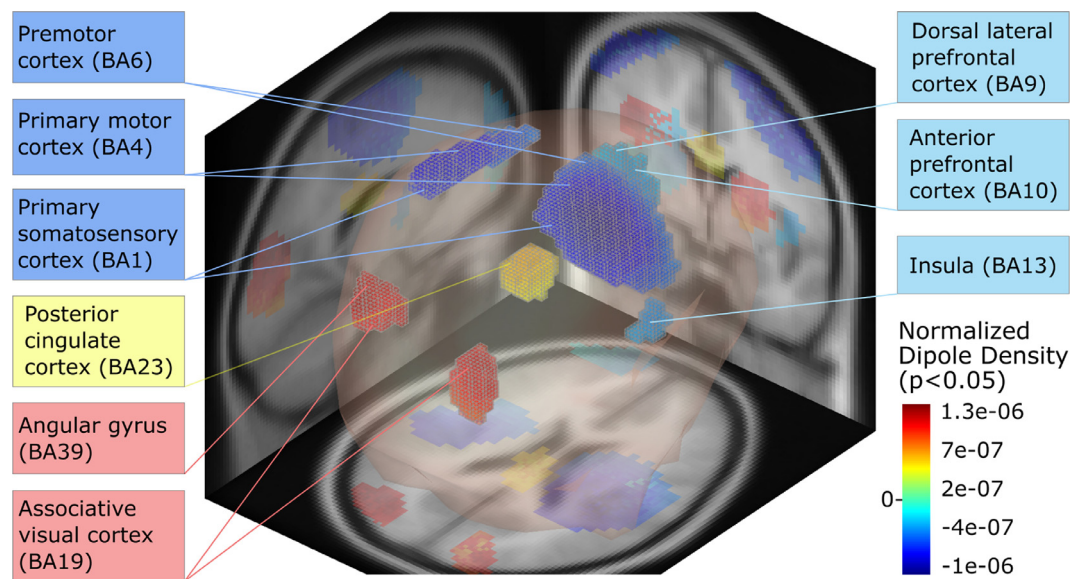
The difference in normalized equivalent dipole density of dipolar brain ICs in AMICA models dominant in emotion periods versus models dominant during baseline periods (i.e., pre- and post-session baseline and relaxation periods), masked by the result of a significance test ($p < .05$) using bootstrapping. The result is superimposed on a 3D brain model with selected sagittal, coronal and axial slices of a template MR image shown for reference. Here Brodmann areas (BA) were identified by their MNI brain template coordinates.
